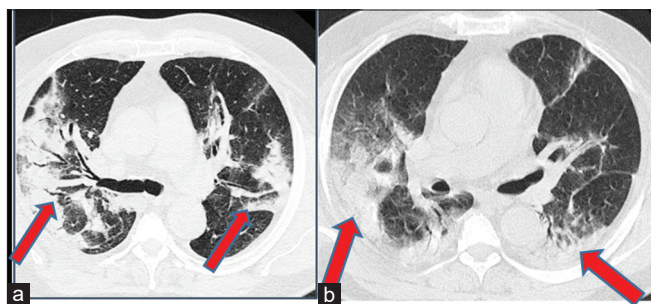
(a and b) Computed tomography scan obtained on illness day 1 shows a mixed pattern with an evident ground glass extent and atelectasis (red arrows) bilateral. The overall consolidation suggests the presence of organizing interstitial pneumonia
